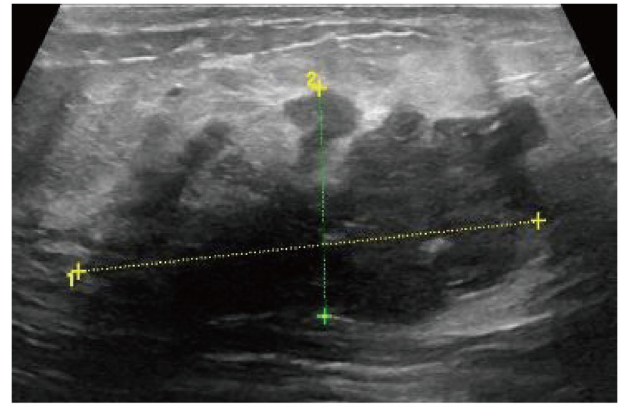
Breast ultrasound revealed a mass.
